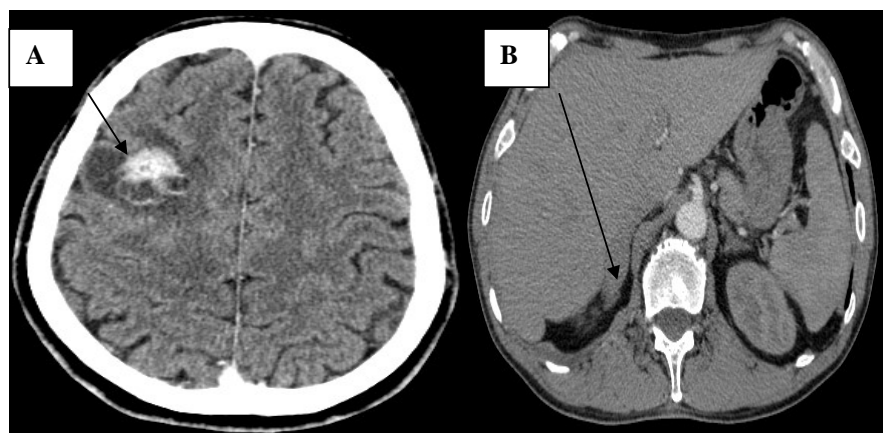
(A) Brain CT-scan, right parietal intra-parenchymal lesion. (B) Abdomino-pelvic scan, right adrenal lesion.
